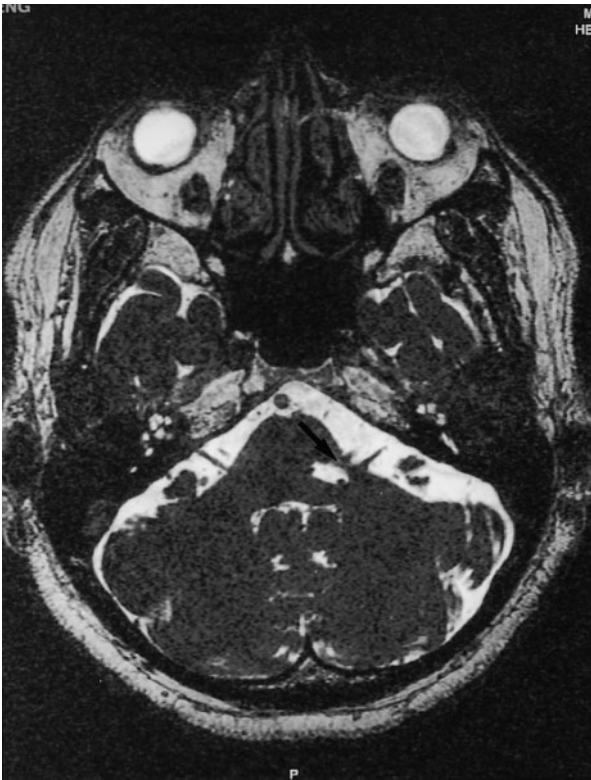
Male, 53 years old, with left-sided HFS. High resolution axial T2-weighted MRI through the pons, demonstrating gross vascular indentation on the left pons at the root exit zone of the left facial nerve (arrow).
